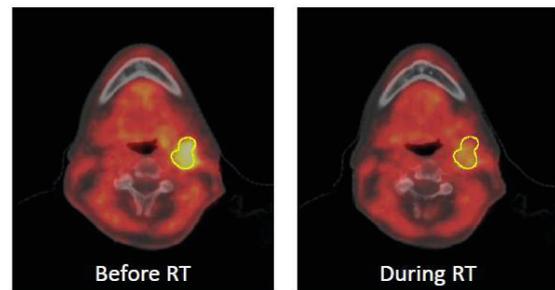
[¹⁸F]HX4 PET/CT transverse view before and during radiotherapy.
